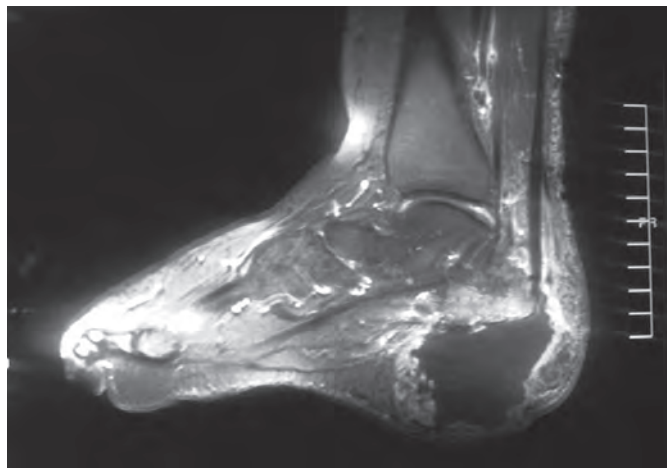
Magnetic resonance image of left foot after partial calcaneectomy.
